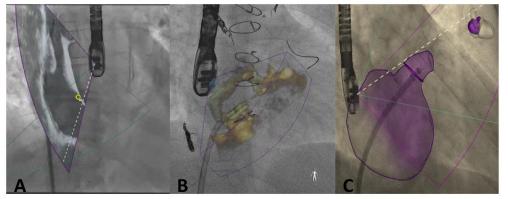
Different echocardiography imaging, such as 2D echocardiography with a *yellow marker* placed at the transseptal puncture site (A), 3D echocardiography (B), and 3D display of automatically rendered structures (C), can be overlaid onto the fluoroscopic screen to guide different procedural tasks. The tip of the catheter is in the LAA.
